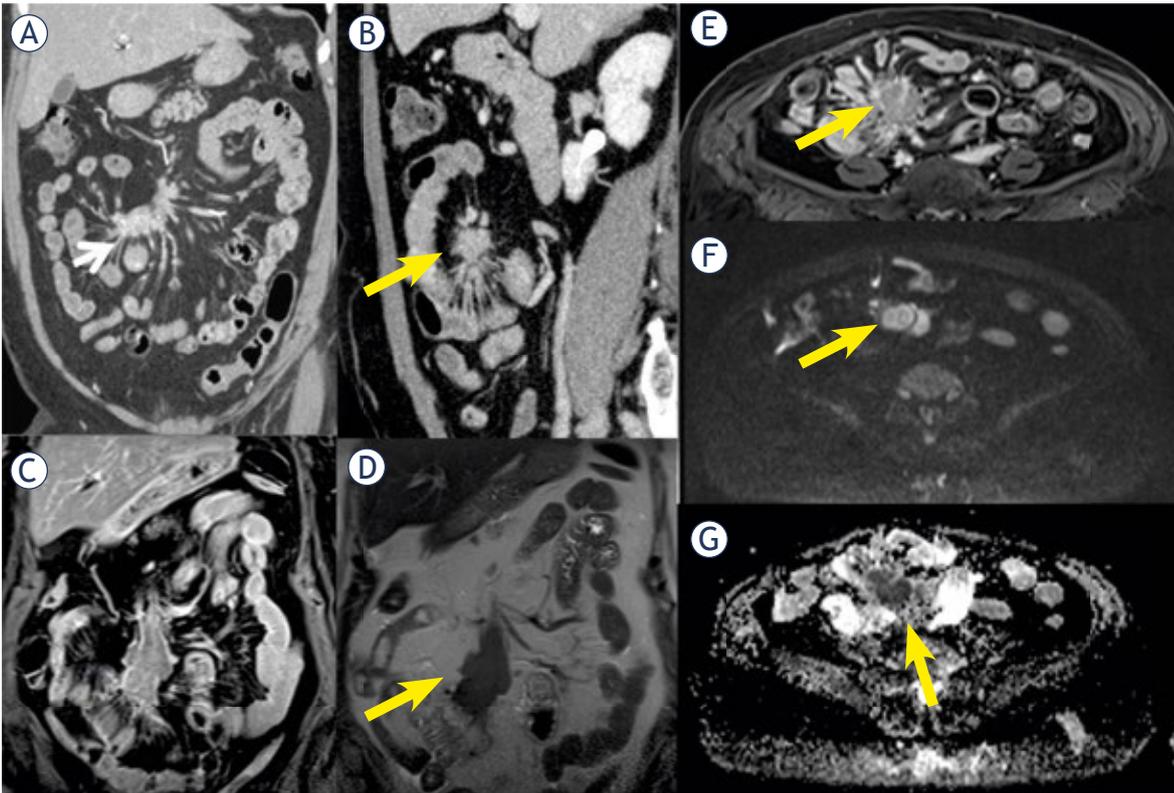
A 48 yrs old male with ileal net. CT during portal phase shows (A, coronal plane and B sagittal plane) desmoplastic reaction in the mesentery and lymphadenopathy (arrow); these features in T1-W post contrast study (C and E portal phase) show hypointense signal (arrow) and hypointense signal (arrow) in T2- W sequence (D) with restricted diffusion (arrow) in b800 s/mm² (F) and hypointense signal in ADC (G) map.
